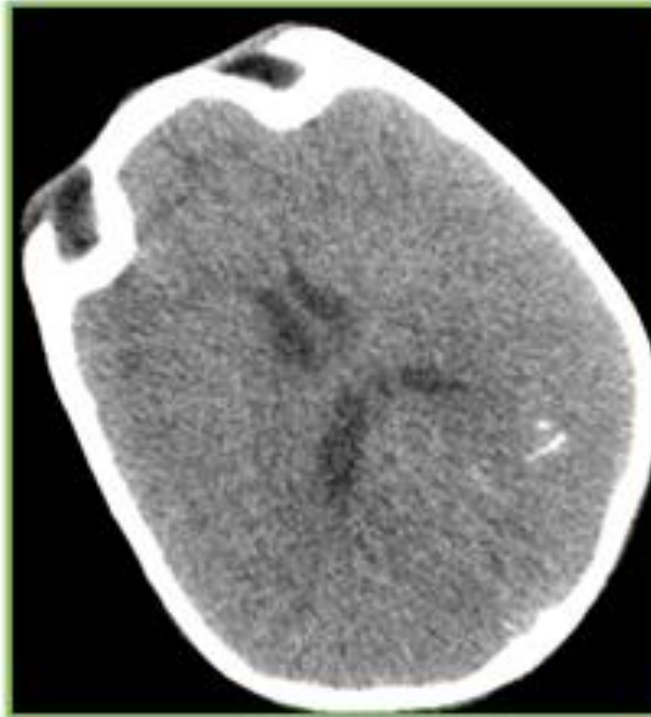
Nonenhanced CT scan in a 3-year old child, shows linear calcification in left parietal region. Diagnosed as mineralizing microangiopathy.
